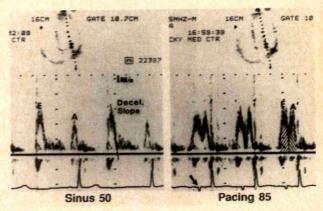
Pulsed-wave Doppler velocity profile from the ap cal 4-chamber view with the sample volume at the level of the mitral anulus. At the spontaneous heart rate of 50 beats/min, peak E velocity is approximately 0.55 m/s, whereas peak A velocity is approximately 0.4 m/s. During atrial pacing at 85 beats/min, peak E velocity is minimally changed, but peak A velocity has increased to nearly 0.6 m/s. Pacing artifact is in dicated by the arrow. Deceleration (Decel.) slope from peak E velocity is indicated by the solid dark line. Cross-hatched areas indicate integrated velocities for early and atrial portions of diastole. A = late atrial filling velocity; E = early passive filling velocity.
